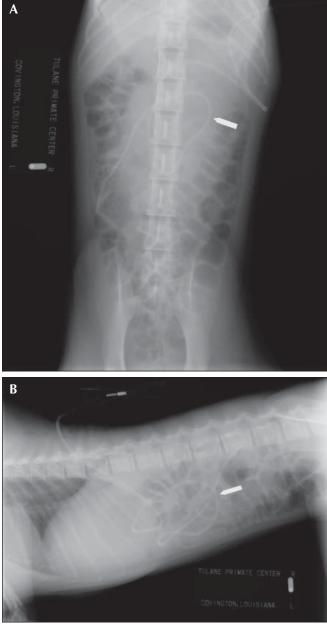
(A) Ventrodorsal and (B) right lateral abdominal radiographs demonstrating a displaced gastric catheter free in the peritoneal cavity.
